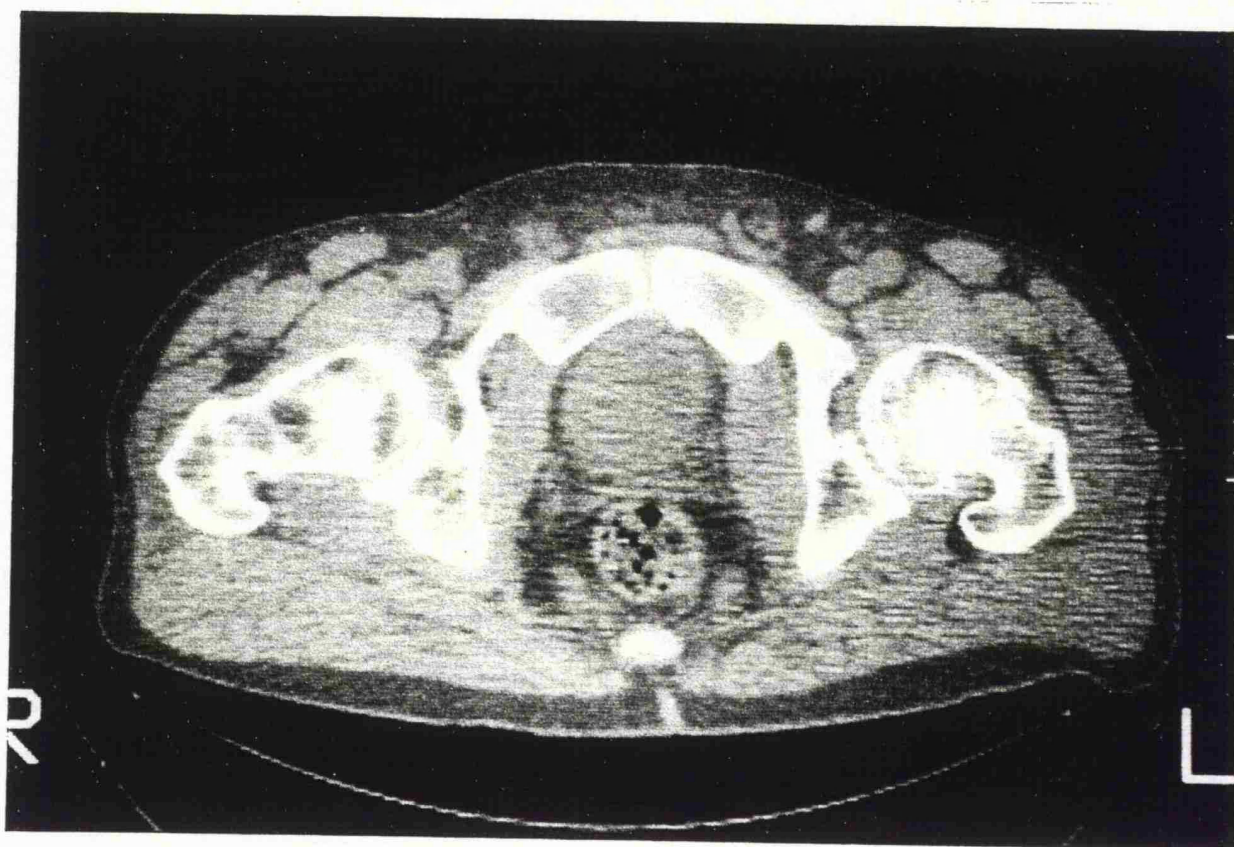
A CT scan of an undisplaced and impacted proximal femoral fracture.
